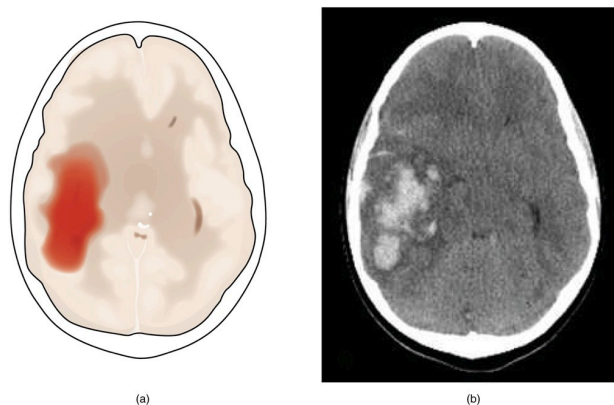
Hemorrhagic Stroke (a) A hemorrhage into the tissue of the cerebrum results in a large accumulation of blood with an additional edema in the adjacent tissue. The hemorrhagic area causes the entire brain to be disfigured as suggested here by the lateral ventricles being squeezed into the opposite hemisphere. (b) A CT scan shows an intraparenchymal hemorrhage within the parietal lobe. (credit b: James Heilman)
